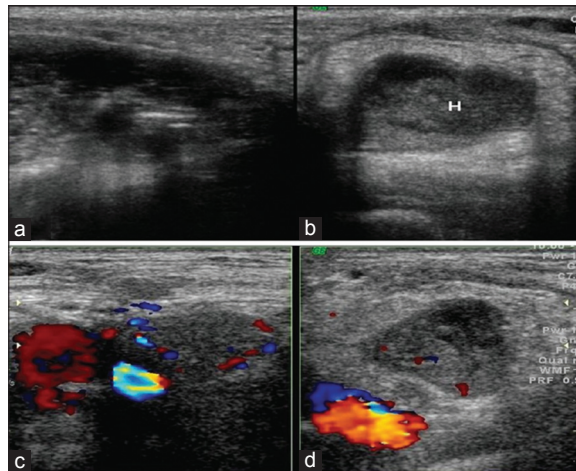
Femoral hernia - ultrasonography with color doppler.
